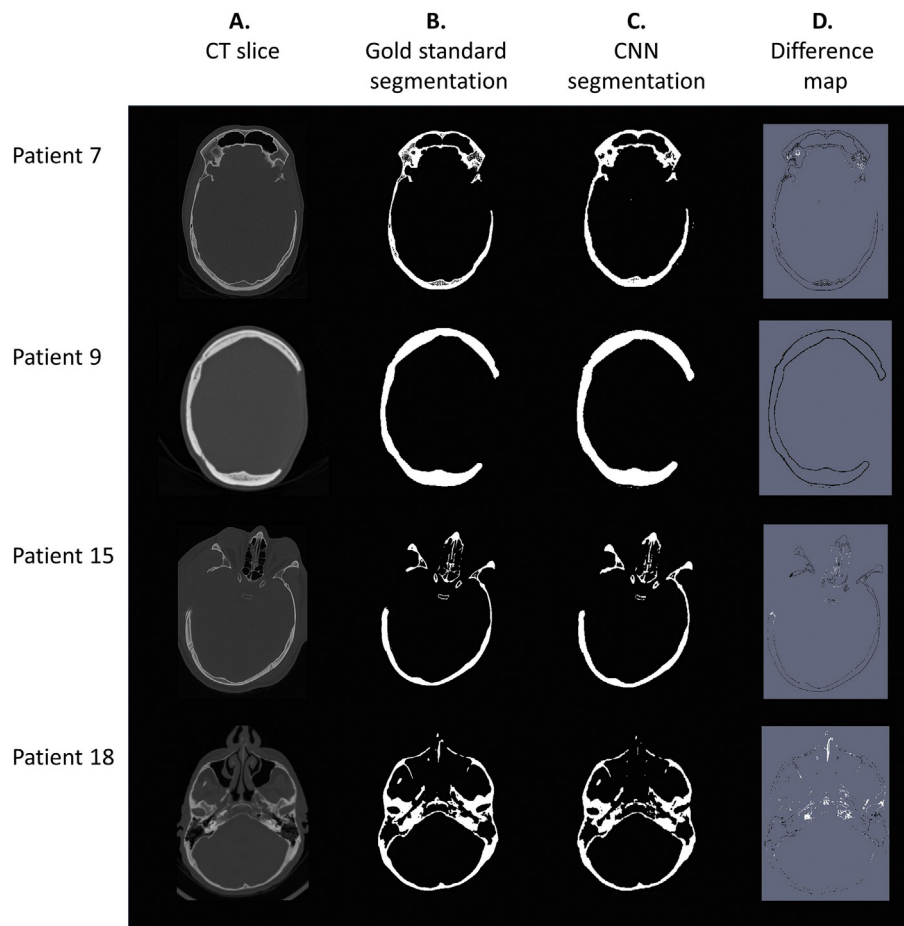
Example of four axial CT slices of patients with a skull defect (A), the corresponding gold standard segmentation (B), the CNN segmentation (C), and the differences between the gold standard segmentation and the CNN segmentation (D).
